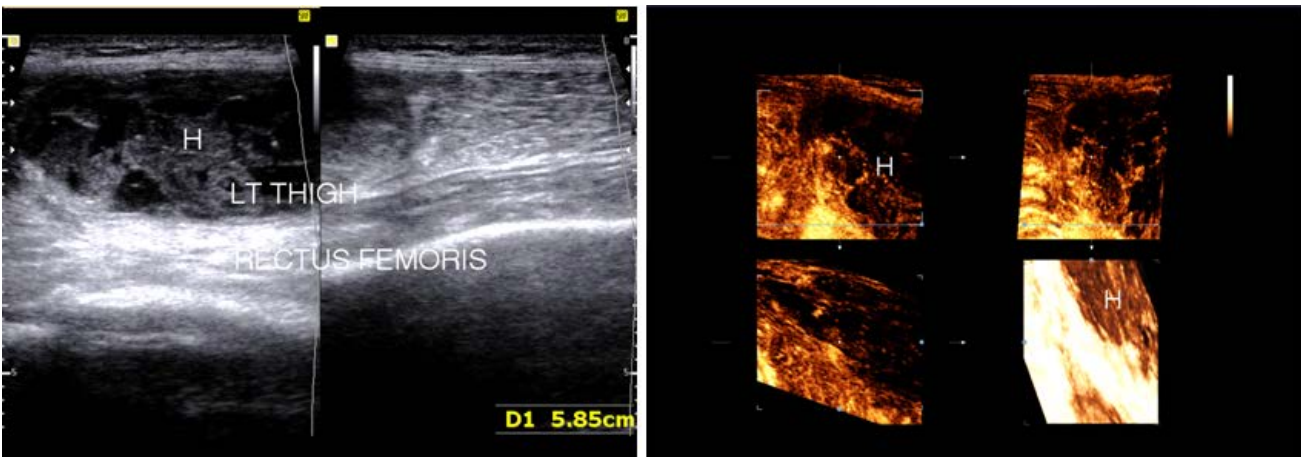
2D sonography of intra muscular hematoma with clotted blood (H), b. 3D reconstruction of intramuscular hematoma (H)
